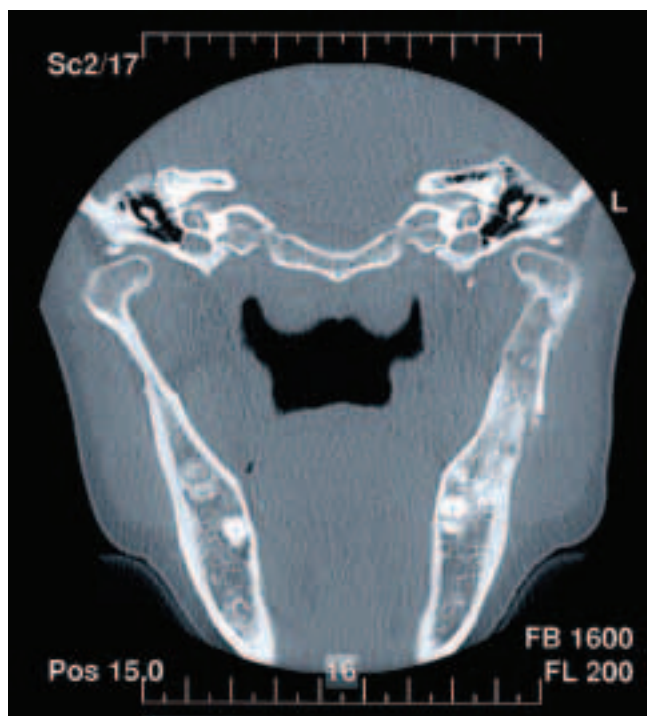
Controlling CT-scan section after 6 months post operatively showing the coronoid cover
